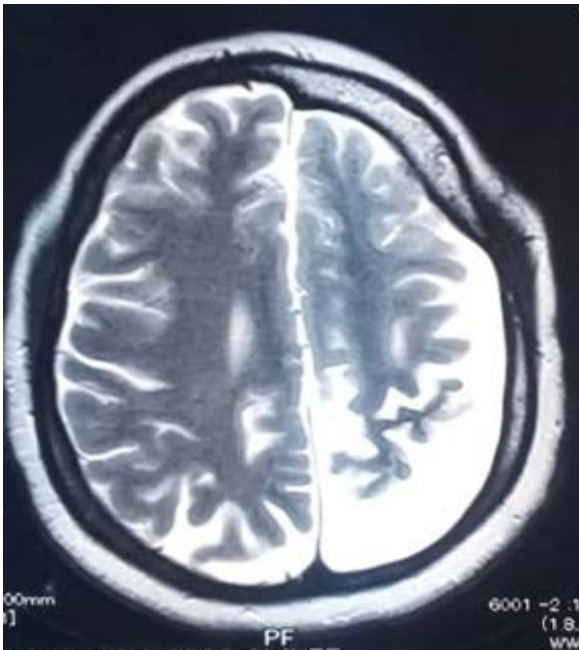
Cerebral MRI sequence T2: Hemileft cerebral atrophy with compatible cortical calcifications at the Sturge Weber's disease.
